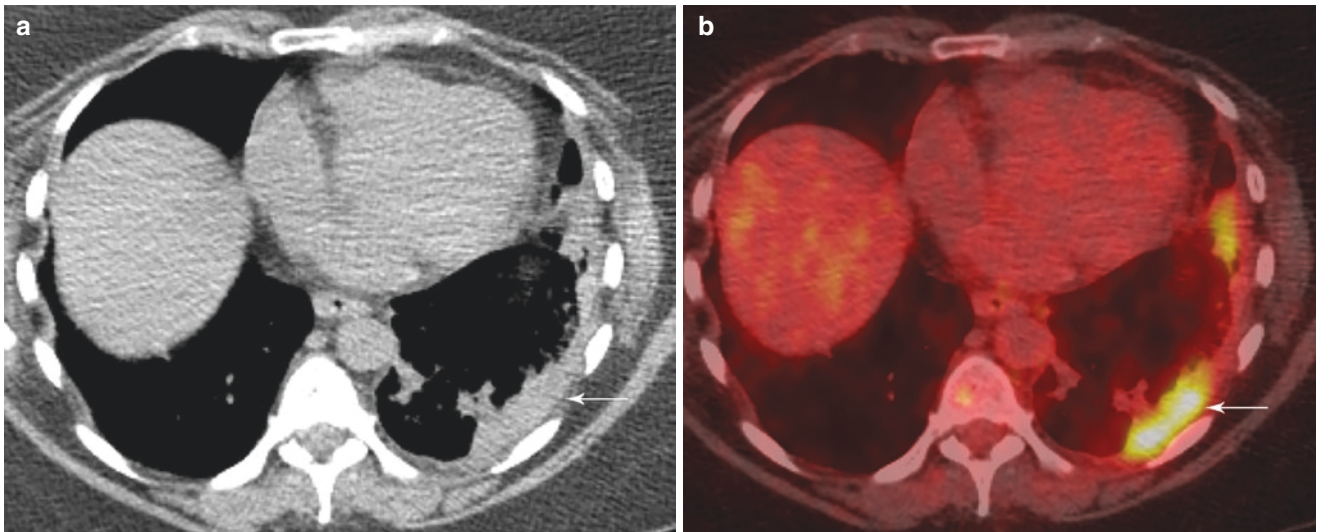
(a) Non-contrast axial CT shows left posterior pleural thickening (arrow); (b) axial FDG-PET/CT shows intense FDG avidity of the left pleural thickening (arrow)
